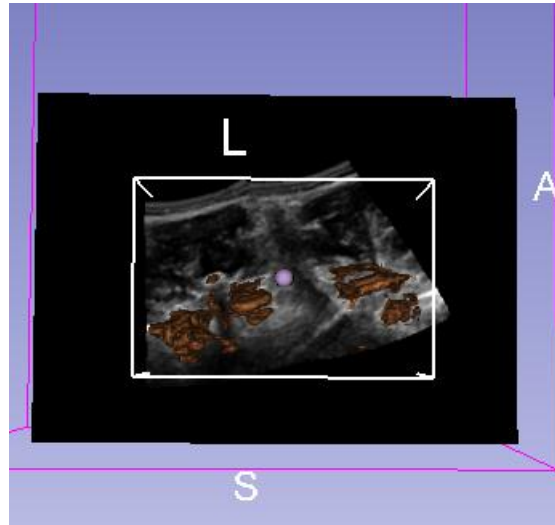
An isosurface (brown) is shown overtop an ultrasound image.
